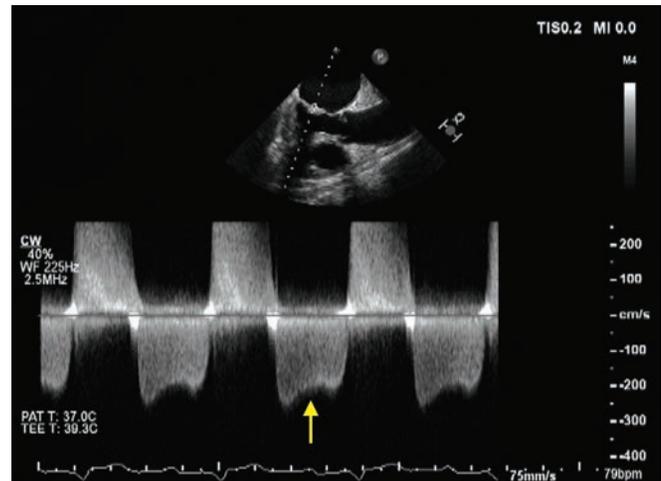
CW Doppler shows a flat MV diastolic slope (arrow)
